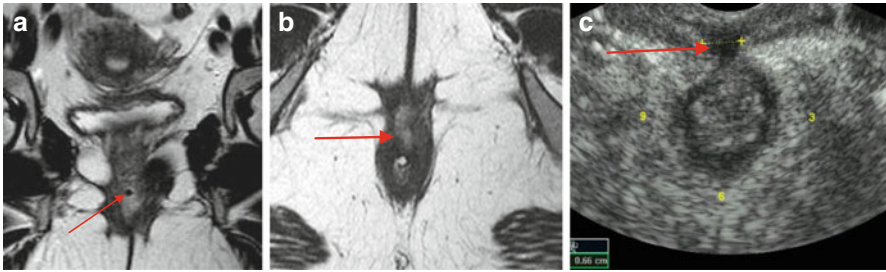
IFIP in a 32-year-old woman with fourth degree tear, disruption of the right pubococcygeal muscle, anovaginal fistula (*arrow*), and left-sided temporary colostomy after rectal suture repair and subsequent dehiscence (a). Contemporary axial STIR image showing the abnormal anovaginal communication as a focal change with increased signal intensity (*arrow*, b), and persistent hypoechoic lesion located at 12 o'clock position seen by 2D ultrasonography (*arrow*, c) 6 months later
